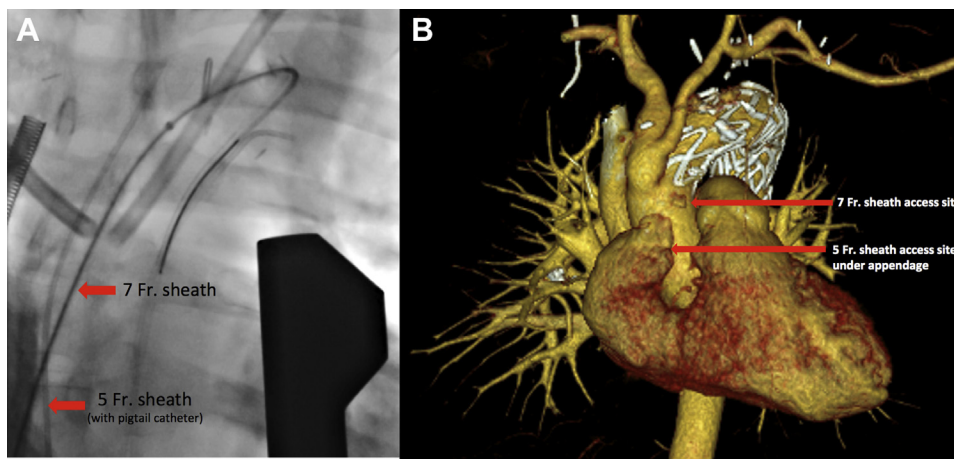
A, Intraoperative fluoroscopic image demonstrating antegrade sheath placements in the ascending aorta. The more proximal 5F sheath was placed for flush catheter imaging and the 7F sheath for wire access. B, One-year postoperative computed tomography angiogram three-dimensional reconstruction showing pledgeted repair of the 7F cannulation site; the 5F site lies underneath the right atrial appendage. The thoracic endovascular aortic repair pieces were well seated and expanded, with good arch flow and supra-aortic trunk flow. No endoleak or flow was present in the left subclavian artery aneurysm, which had regressed to 2.5 cm.
